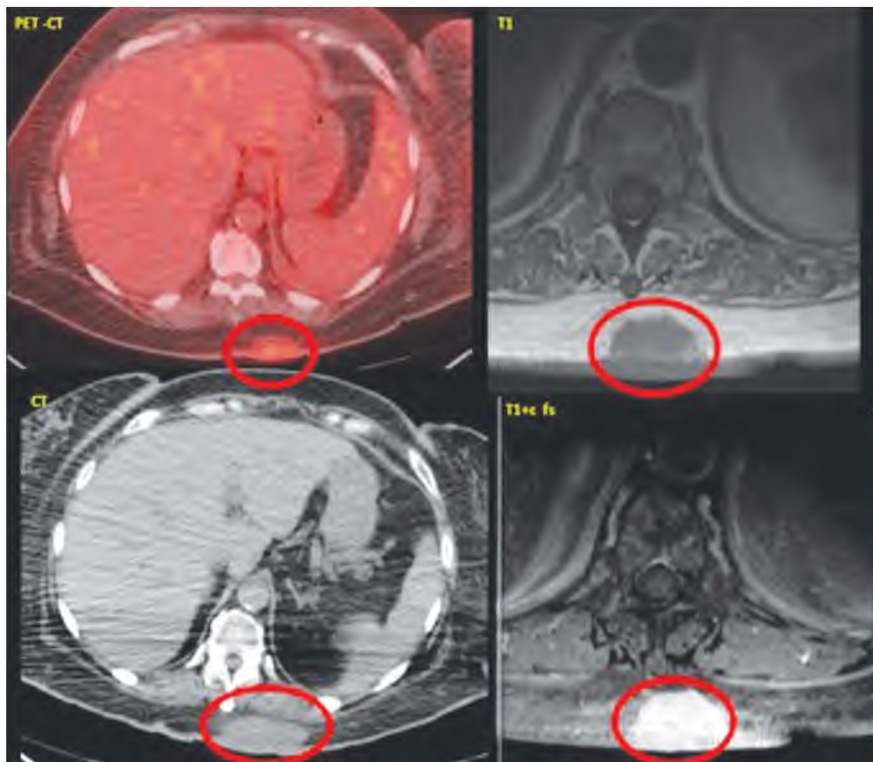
PET CT, axial CT, Pre and post contrast MRI images for 61-year-old female with known uterine cancer, PET / CT revealed midline mid back well-defined subcutaneous lesion with FDG avid lesion, SUV max 10, MRI show avidly enhancement Pathology revealed metastatic lesion.
